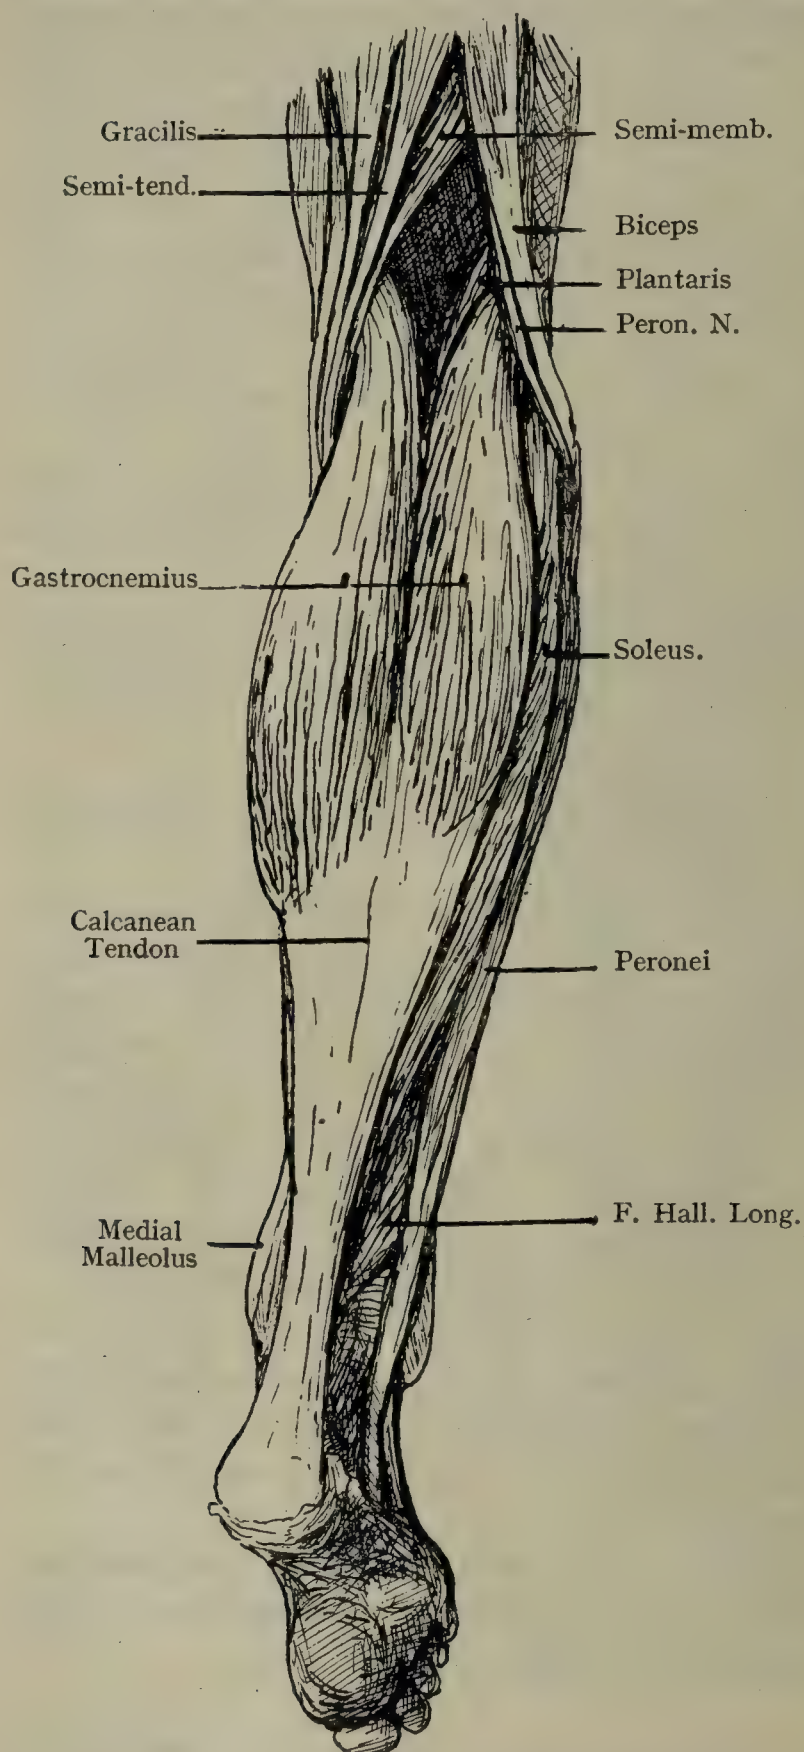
SUPERFICIAL ASPECT OF MUSCLES OF CALF.
